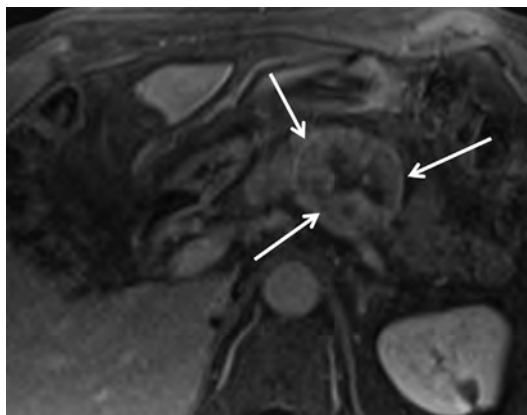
In a 62-year-old man with a history of renal cell carcinoma who had undergone a right nephrectomy, MRI shows a heterogeneously enhancing pancreatic body/tail (*arrows*), indicating renal cell carcinoma metastasis.
